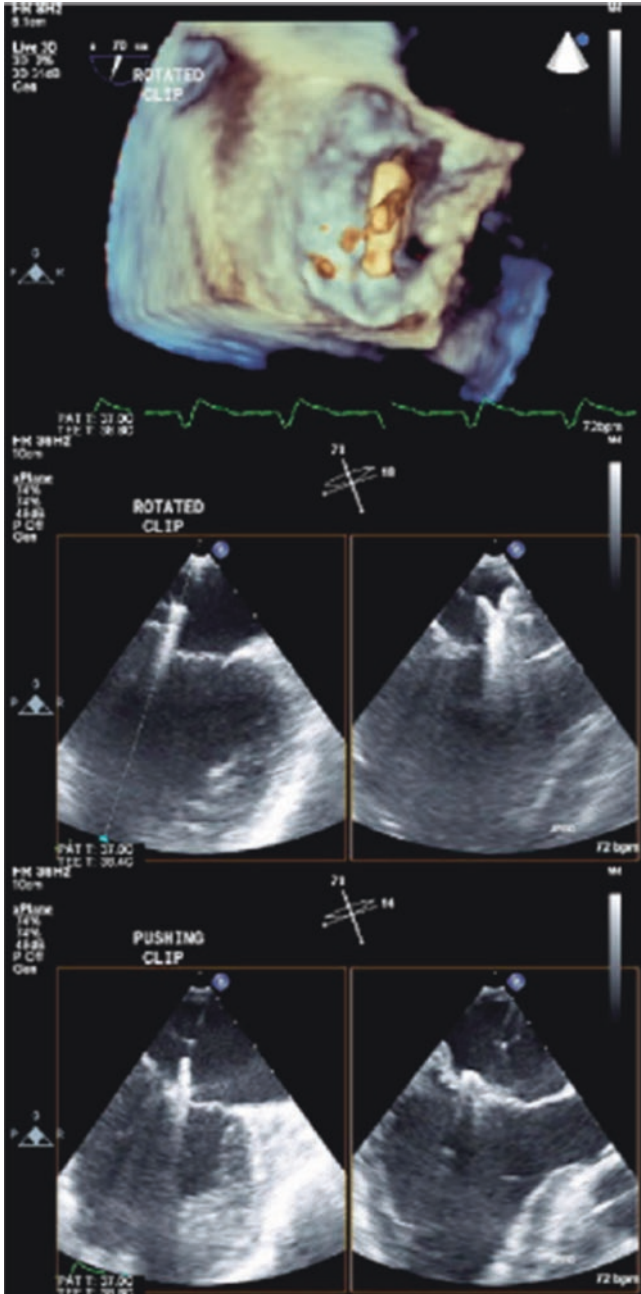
Three-dimensional echocardiography and mitral valve clip. In the mitral valve clip procedure, real-time 3D echocardiography identifies the position of the clip with respect to the mitral valve, in the enface perspective (*top panel*). The accurate positioning of the mitral clip often relies on simultaneous biplane imaging that more precisely defines the relationship between the arms of the clip with the valve leaflets (*bottom panel*)
